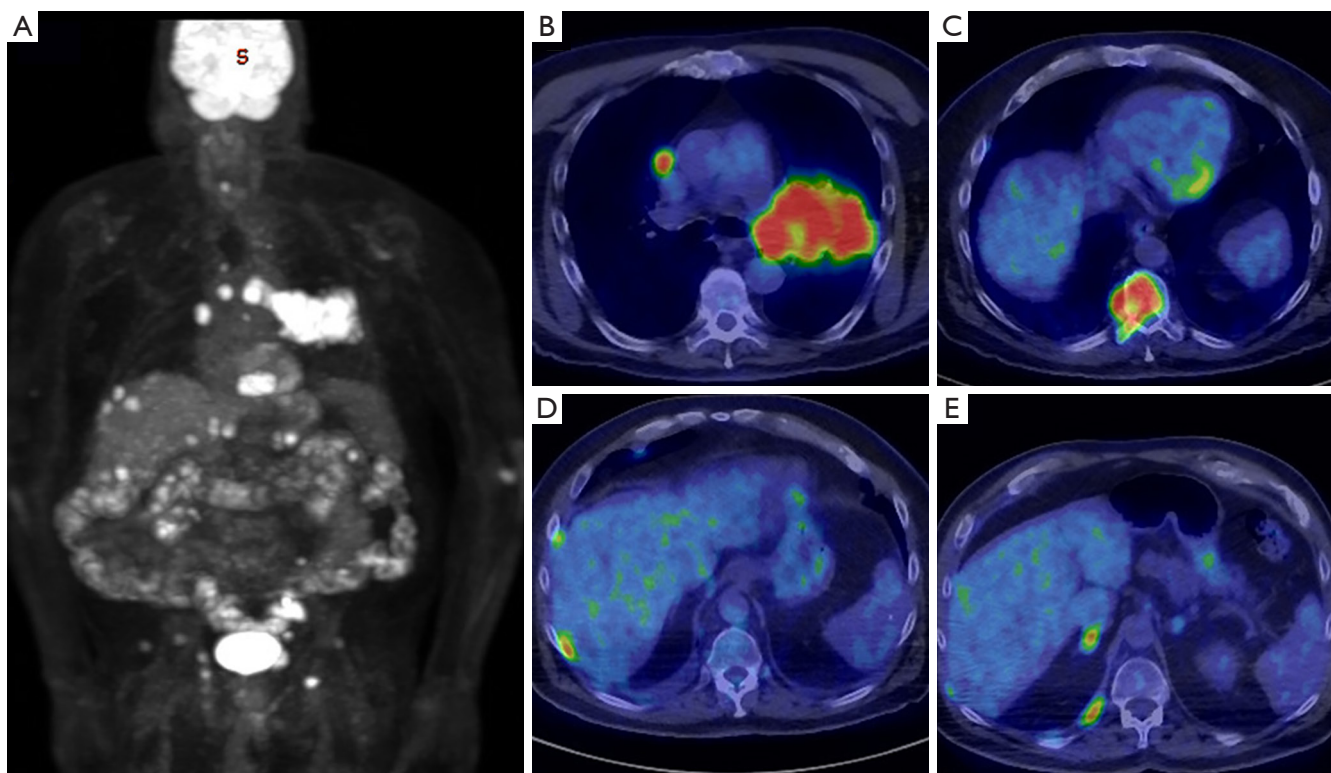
A 74-year-old male presenting with shortness of breath and fatigue. MIP reconstruction from FDG PET (A) shows a large FDG avid left small cell lung cancer with numerous additional foci of abnormal uptake throughout the body. Fused axial PET/CT images reveal that bilateral hilar lymph nodes (B), vertebral body (C), liver (D), and the adrenals (E) have metastatic disease.
